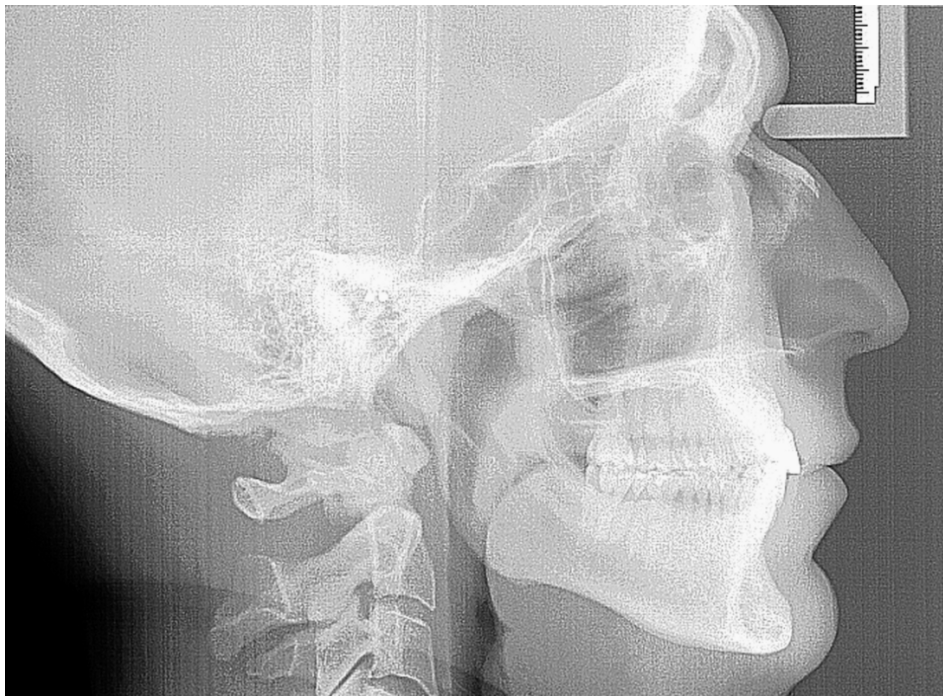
Lateral Cephalometric Radiograph with Nasion support and millimeter ruler
